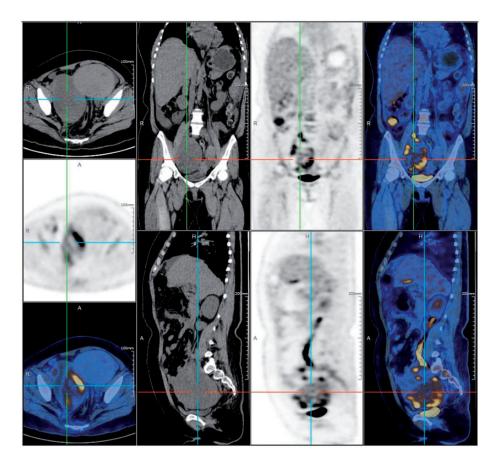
Positron emission tomography/computed tomography shows disseminated ovarian cancer with metastasis in the abdomen and pelvis.
